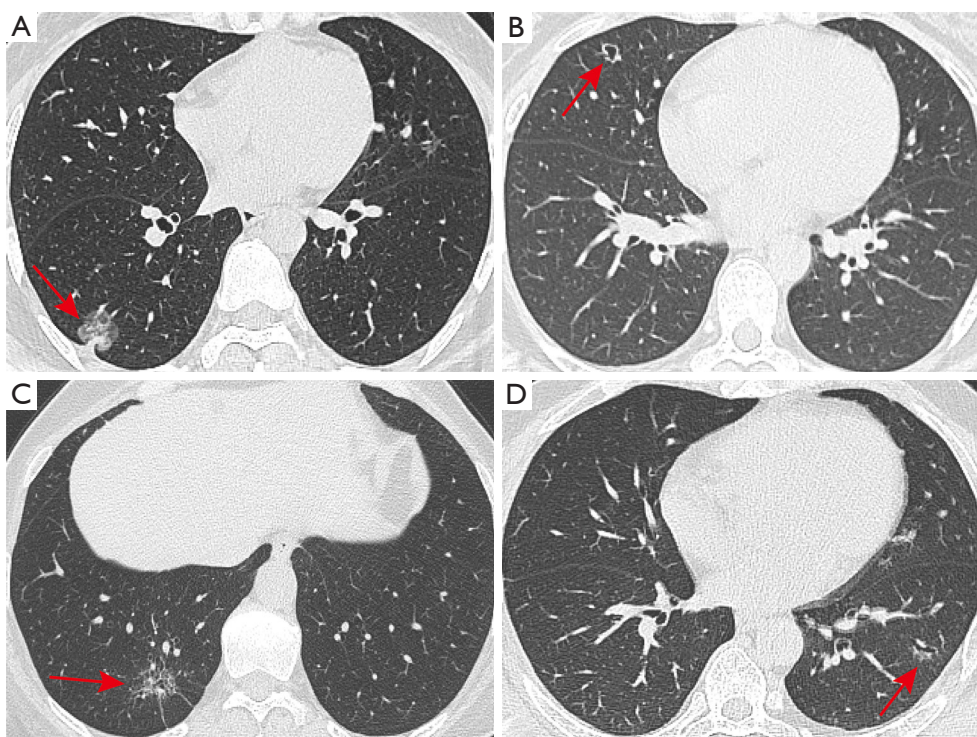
Axial CT images show examples of CT features of ciliated muconodular papillary tumors. (A) A 42-year-old female with a ciliated muconodular papillary tumor. CT scans show part of the solid nodule (red arrow) with lobulation contours and pleura retraction in the right lower lobe. (B) A 37-year-old female with a ciliated muconodular papillary tumor. CT scans show a well-defined nodule (red arrow) with an air-containing space in the right middle lobe. (C) A 58-year-old female with a ciliated muconodular papillary tumor. CT scans show part of the solid nodule (red arrow) with an air-containing space and pleura retraction in the right lower lobe. (D) A 58-year-old female with a ciliated muconodular papillary tumor. CT scans show part of the solid nodule (red arrow) with an air bronchogram in the left lower lobe. CT, computed tomography.
